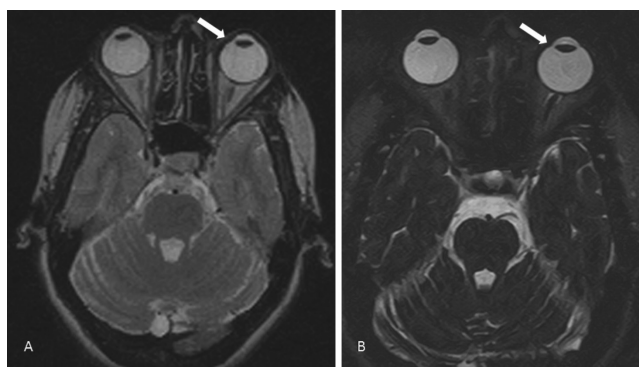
Axial 5 mm-thickness T2-weighted image (A) and thin heavily T2-weighted 1 mm section (B) showed no lesion in the eyeball (arrows)
